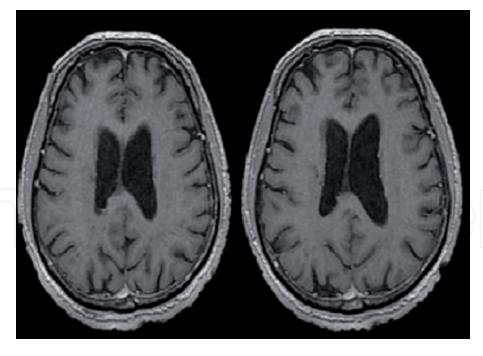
Complete resolution of the lesion is seen after proper antibiotic treatment. The post gadolinium MRI scan was done for control purposes after 1 year.
